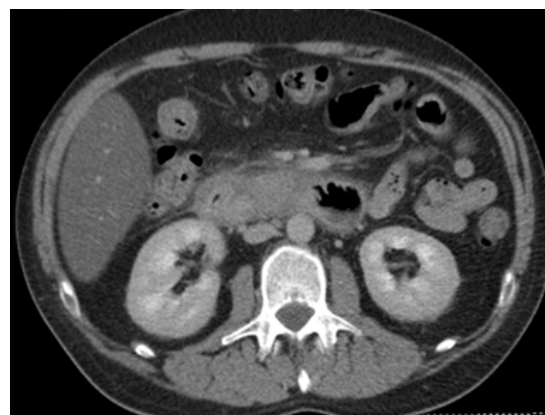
Computed Tomography of abdomen: Duodenum wall edema.
